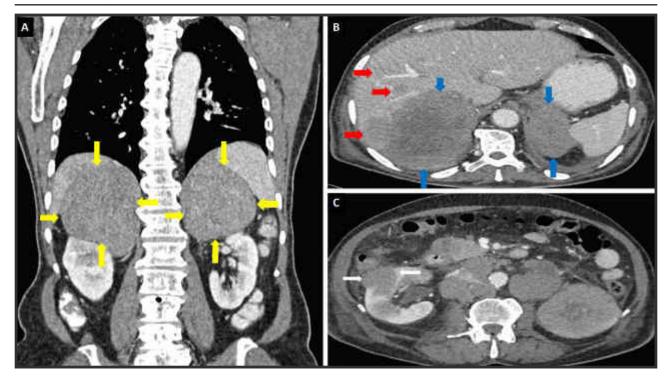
CT scan abdomen and pelvis with intravenous contrast (venous acquisition phase)
